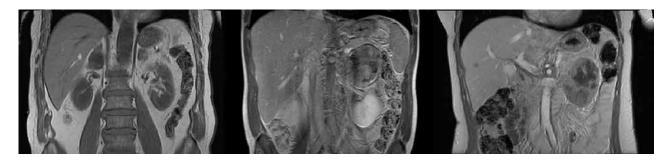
Coronal magnetic resonance images of phaeochromocytomas in JK, MK, and PK (starting from the left) Rycina 2. MR — projekcje czołowe guzów chromochłonnych u JK, MK, PK
